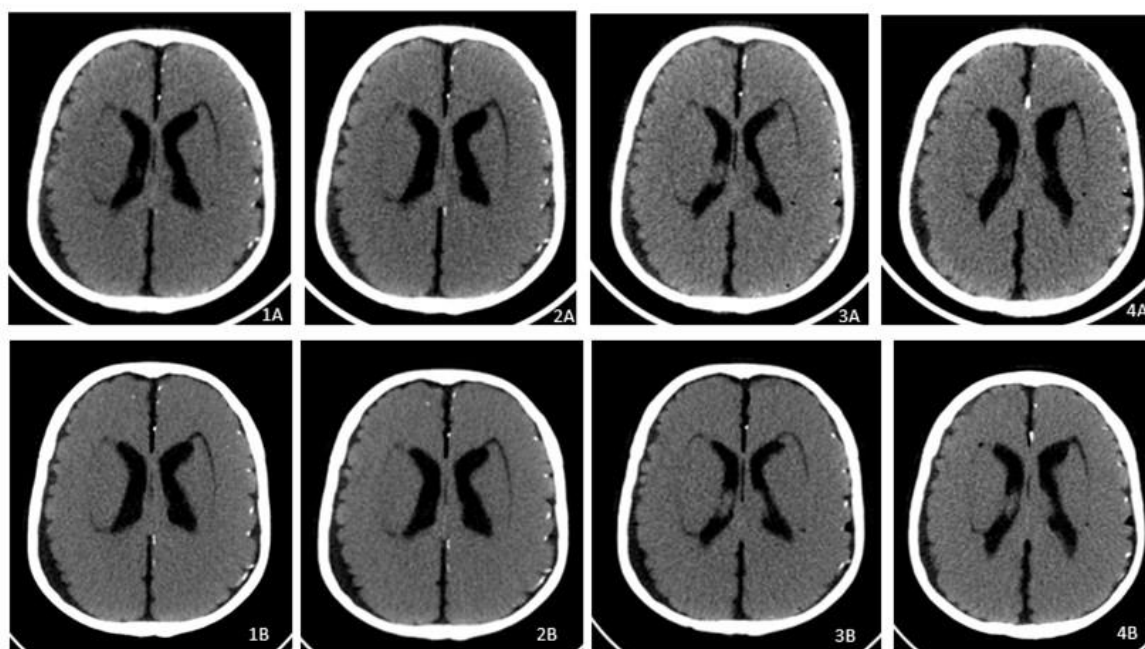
CT transaxial brain image of 32-MDCT (A) and 64-MDCT (B) in each scanning mode. 1: helical with ATCM, 2: helical without ATCM, 3: axial without ATCM, 4: tilted axial without ATCM.
